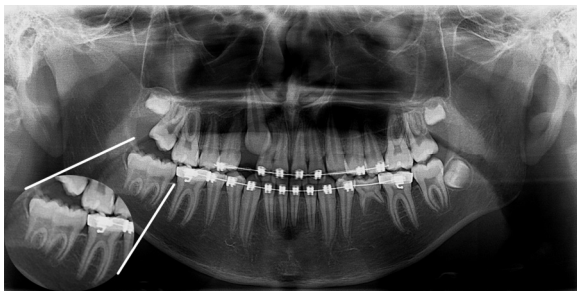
Second radiography, three years later, showed a second molar (mandibular right) had two separate canals and shared one (second molar mesial root and first molar distal root).
